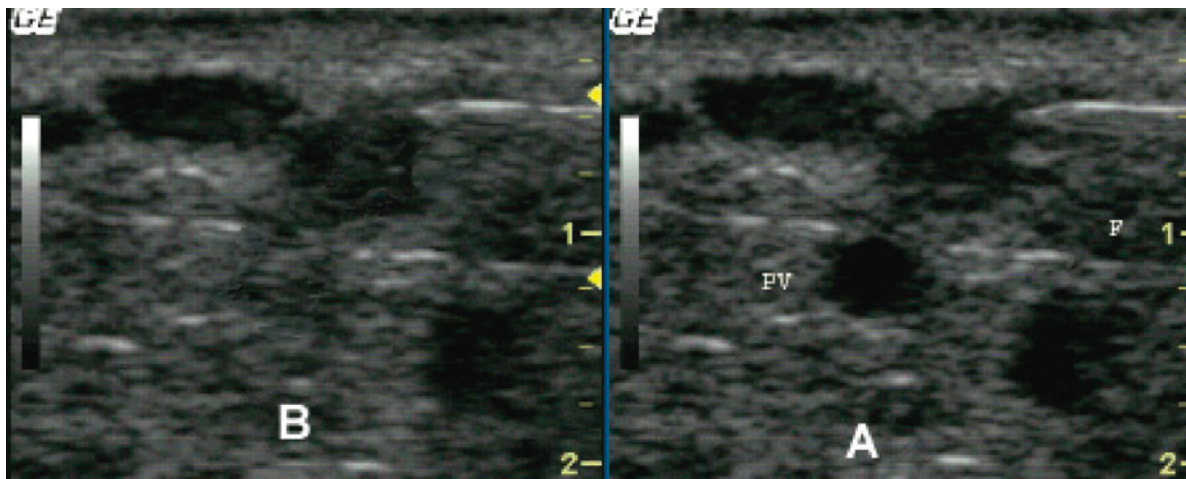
Ultrasound-guided sclerotherapy of the perforating vein. A. The needle is placed in a vein above the fascia (F). B. After an injection the perforating vein (PV) is filled with an echogenic material and has no flow.
